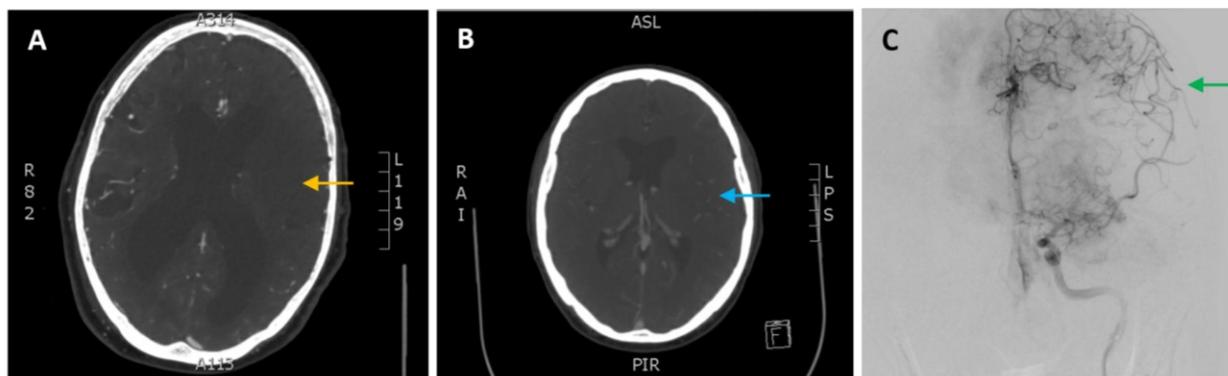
Collateral imaging; in left Middle Cerebral Artery M1 occlusion AIS. A: CT Angiography with poor collaterals (yellow arrow). B: CT Angiography with good collaterals (blue arrow). C: Collaterals as visualized on conventional angiography (green arrow).
